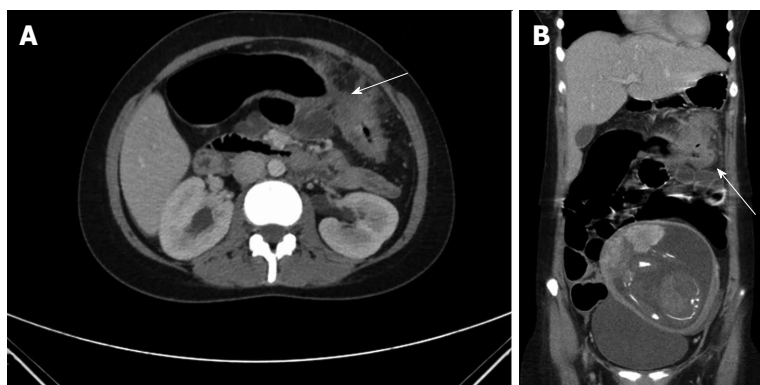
Computed tomography scan images revealing the strictured segment (A) and adjacent phlegmon (B).
